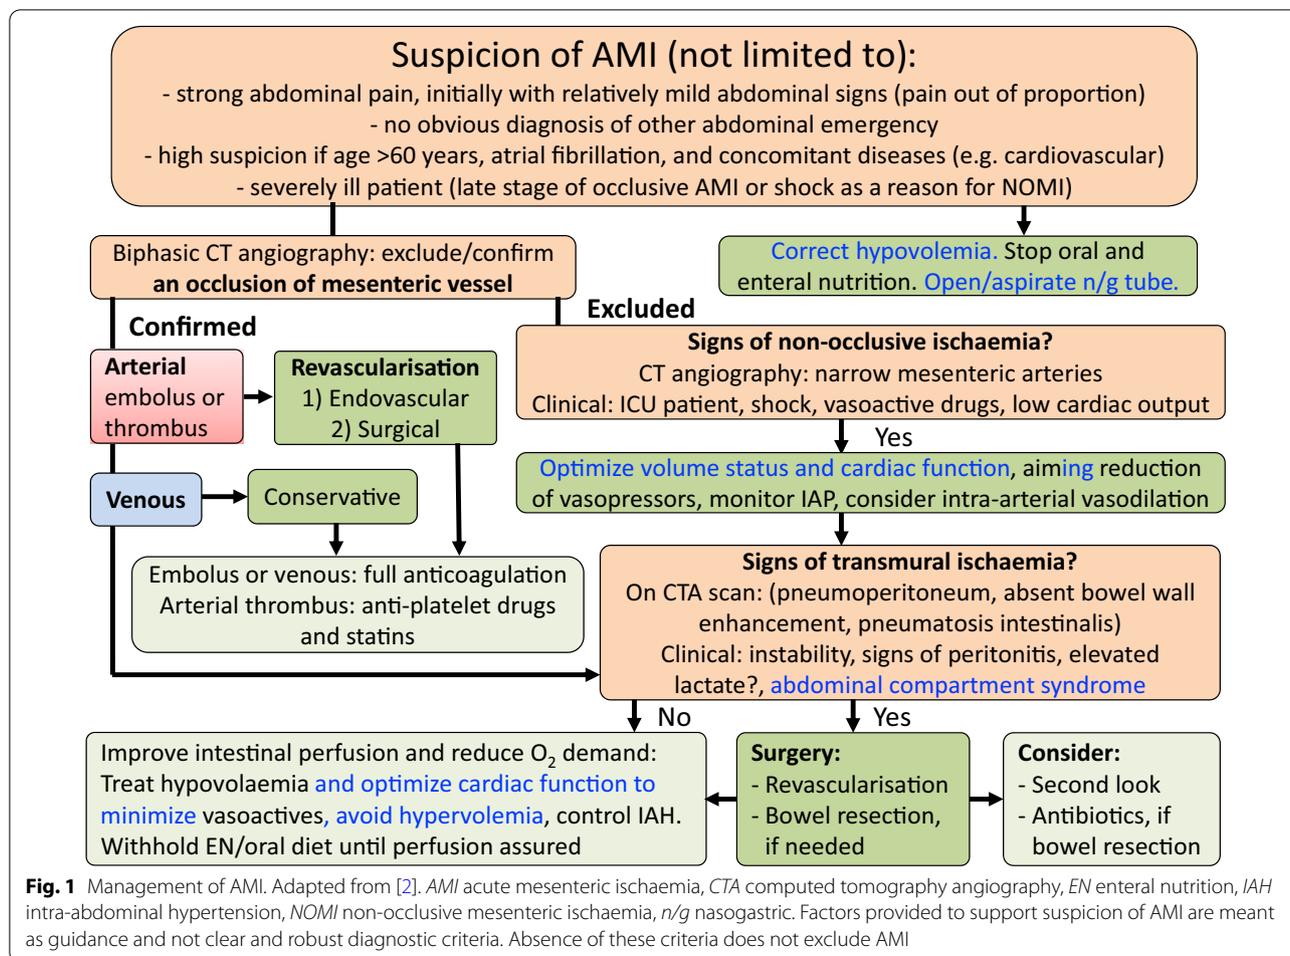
Management of AMI. Adapted from [2]. AMI acute mesenteric ischaemia, CTA computed tomography angiography, EN enteral nutrition, IAH intra-abdominal hypertension, NOMI non-occlusive mesenteric ischaemia, n/g nasogastric. Factors provided to support suspicion of AMI are meant as guidance and not clear and robust diagnostic criteria. Absence of these criteria does not exclude AMI
